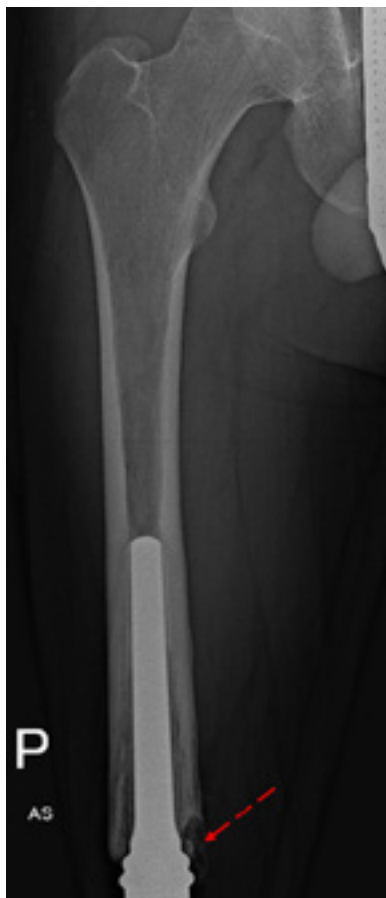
Anteroposterior radiograph of the right femoral stump performed 4 years after the completion of treatment. The area of osteolysis (dashed arrow) at the medial side of the femoral stump
